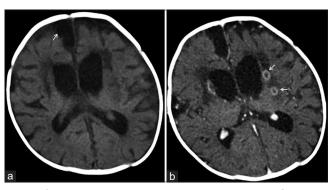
(a) Non-contrast computed tomography (CT) brain demonstrating dilated ventricular system, and extra-axial subdural effusion bilateral (arrow); (b) Contrast-enhanced CT brain showing multiple peripherally enhancing lesions with surrounding edema (arrows) in periventricular brain parenchyma and basal ganglia
